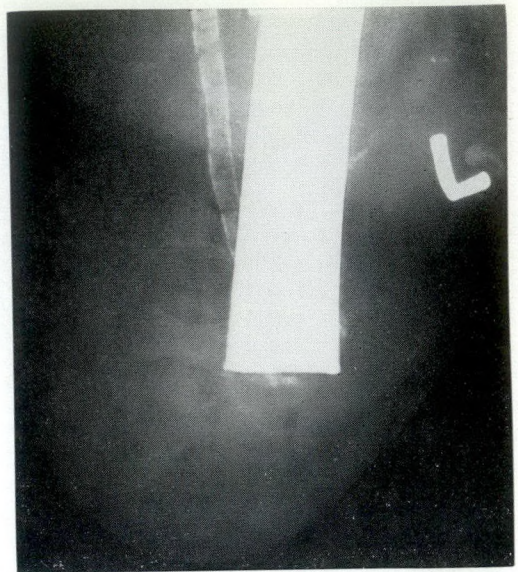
Normal A.K. amputation stump four days postoperatively, for comparison. No gas is seen on radiograph.
